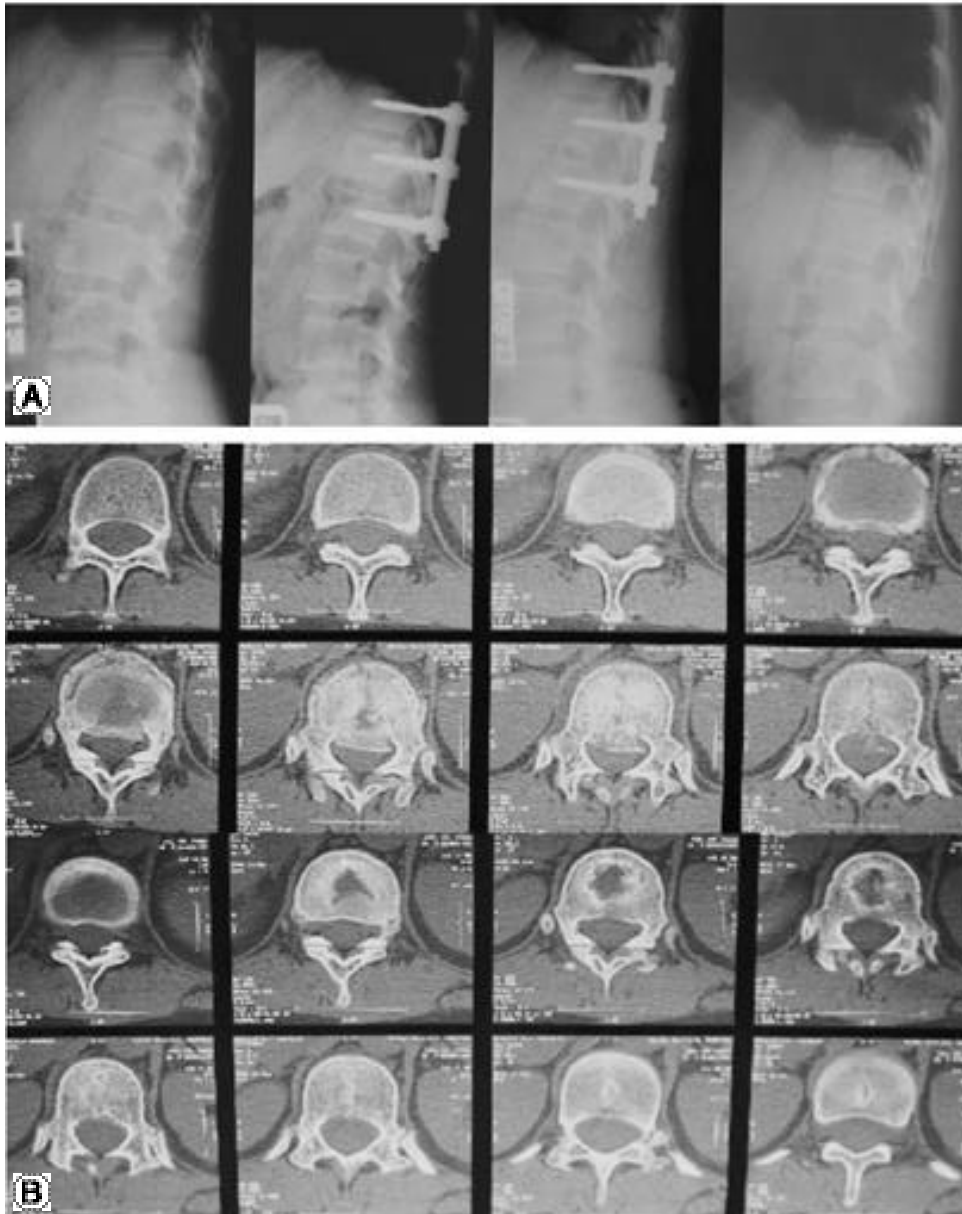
A. Case1: Simple radiograph of a 31 years old female. From the left, at injury, at Postop., at POD 6M., at POD 1Yr. degrees of comperssion was 45.5%, 2%, 3%, 5% respectively. The angle of kyphosis was 22°, 5°, 7°, 8° respectively. At POD 1Yr, the loss of reduction was 2%, and the loss of kyphosis was 3 degrees.
